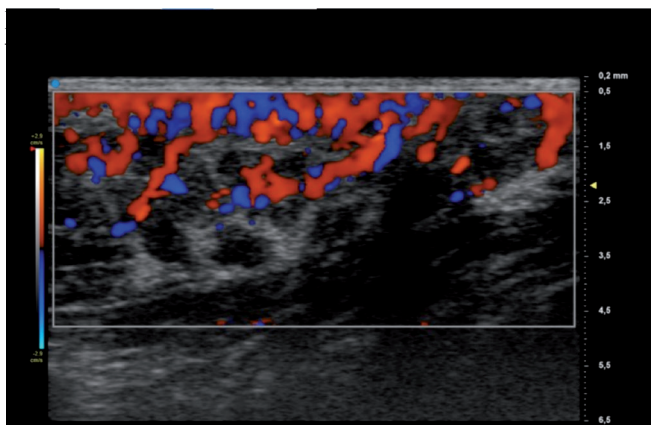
Lymphoma of Fig. 1, color Doppler.
